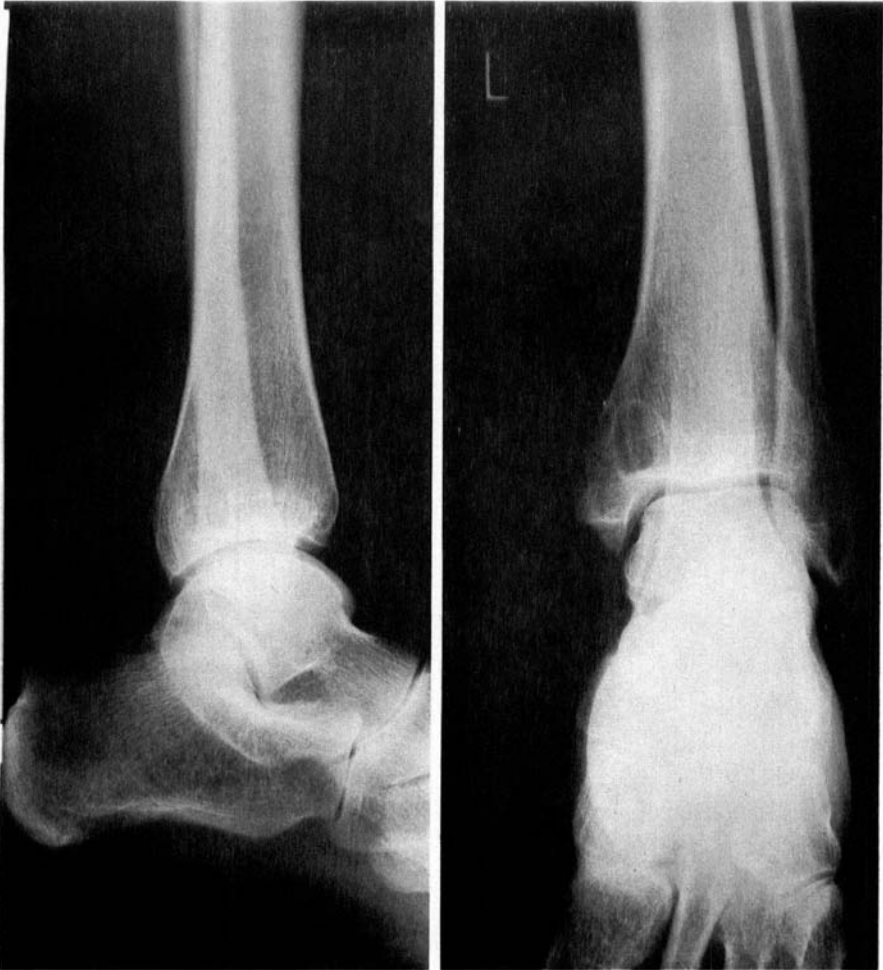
AP and lateral radiograph of the left ankle showing a cystic lesion occupying the medial malleolus.
